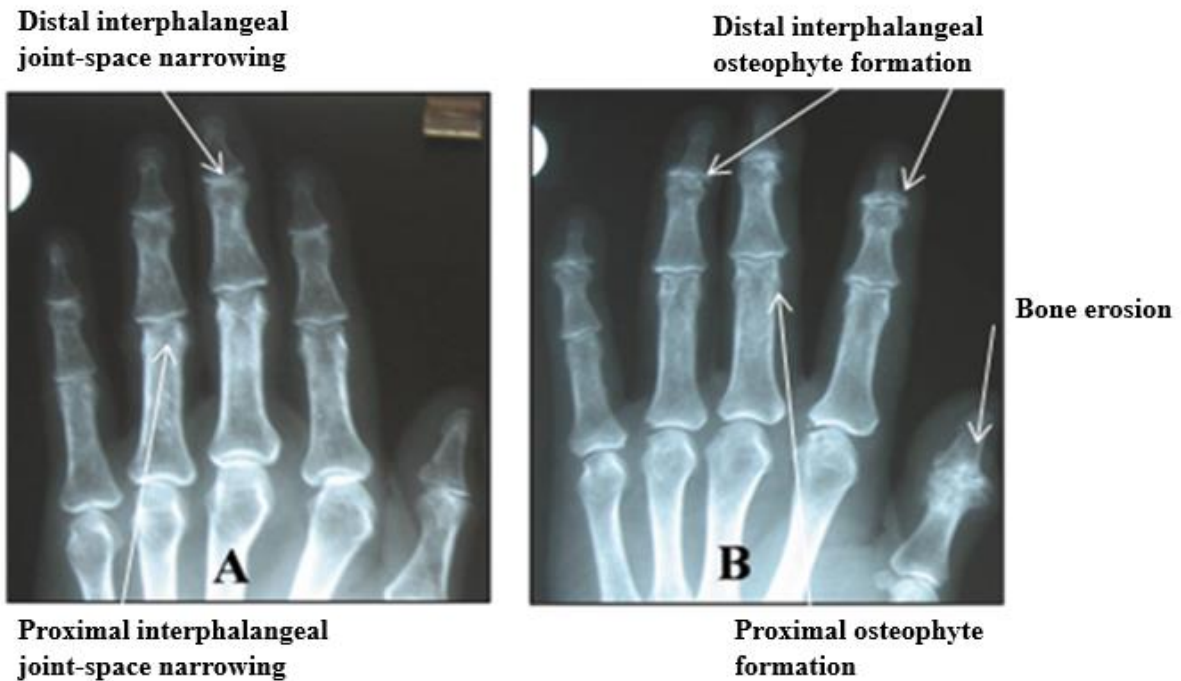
Examples of diagnostic radiographs of patients. (A) Stenosis in distal and proximal interphalangeal joints. (B) Distal and proximal interphalangeal osteophyte formation. Metacarpophalangeal joints were relatively preserved.
